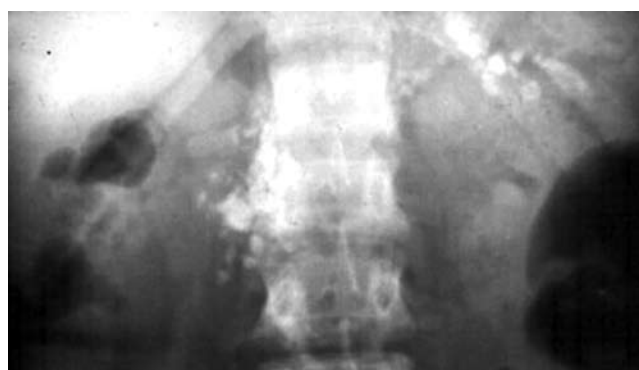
Plain radiograph of abdomen showing calcific opacities in the pancreas in a case of primary hyperparathyroidism with chronic calcific pancreatitis.
